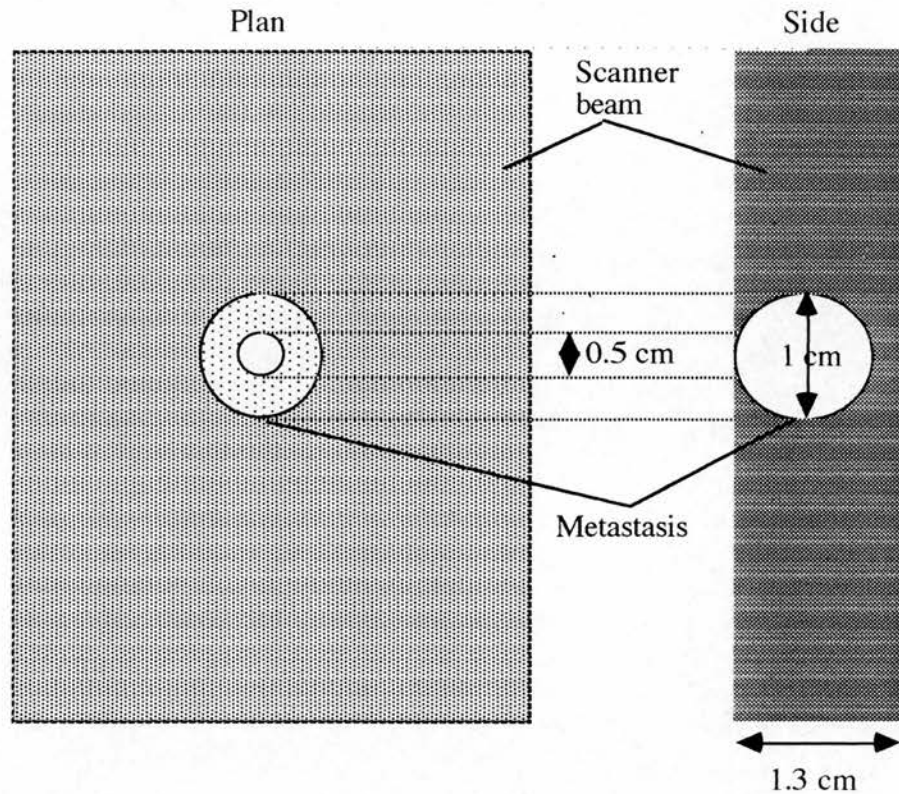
As the size of a metastases approaches the collimation setting of the CT scanner it becomes more difficult to accurately measure its diameter.
